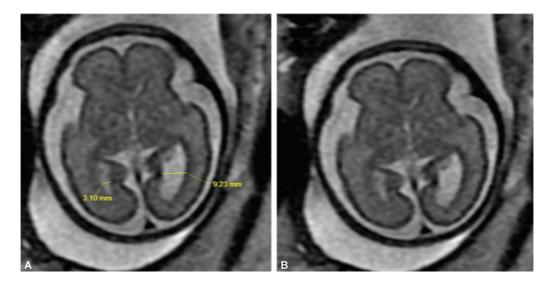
(A, B) Magnetic resonance imagings showing irregular and small left lateral ventricle.
